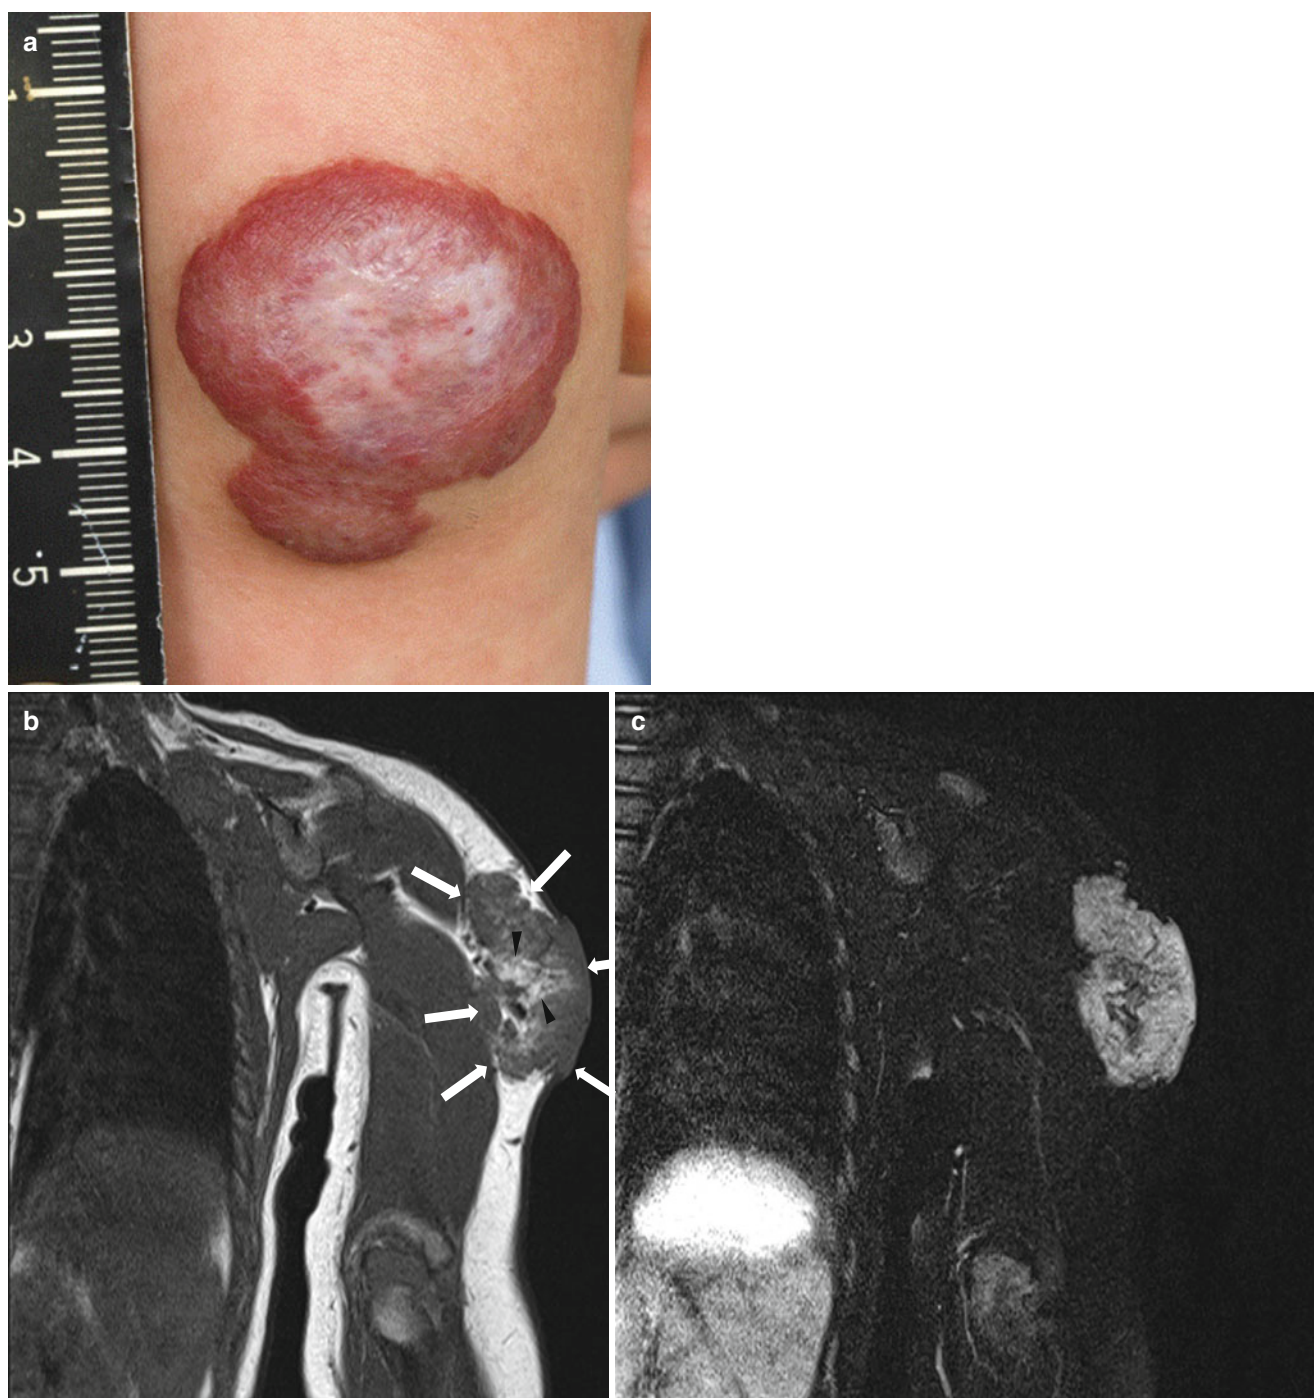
Gross photograph and MR images of an 11-month-old girl with infantile hemangioma at the left arm. (a) Gross photograph shows a superficially located strawberry-like lump. (b) Coronal T1-weighted MR image shows well-defined isointense soft tissue mass (*arrows*) relative to muscle in subcutaneous through cutaneous layer of the Lt. arm. Intralesional high signal intensity portions (*arrowheads*) suggest
